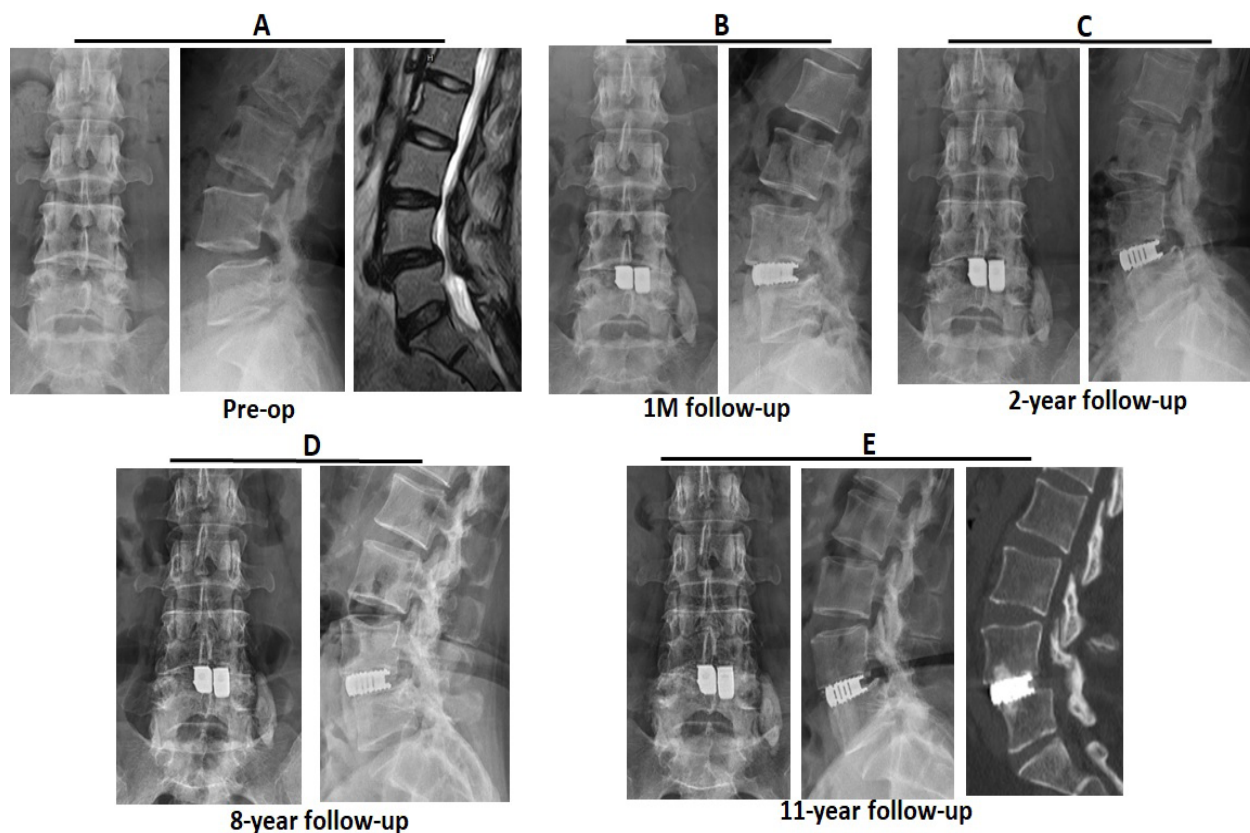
A 53-year-old female with L4/5 DLS and spinal stenosis (A) received CLIF with asymptomatic cement leakage into paraspinal space. The radiographs demonstrate the initial post-operative (B), 2-year (C), 8-year (D) and 11-year (E) follow-up.
